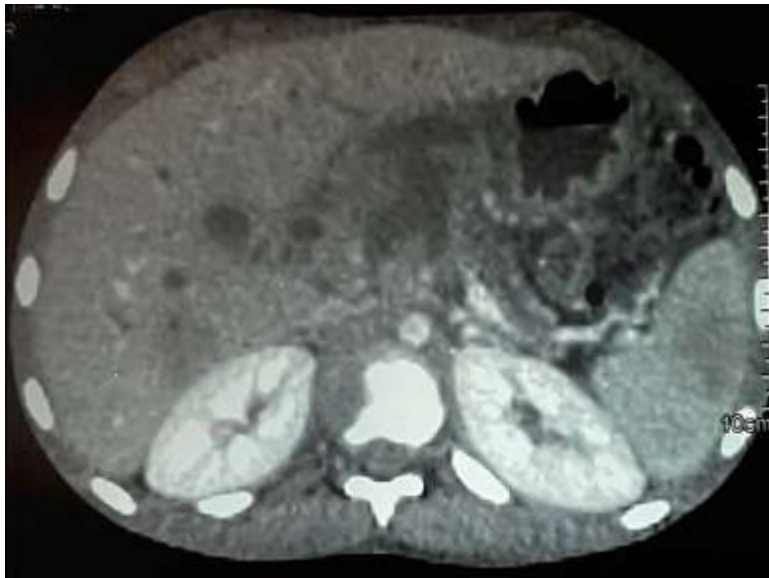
Abdominal CT scan revealing a tumor process centered on the head and isthmus of the pancreas, locally advanced.
